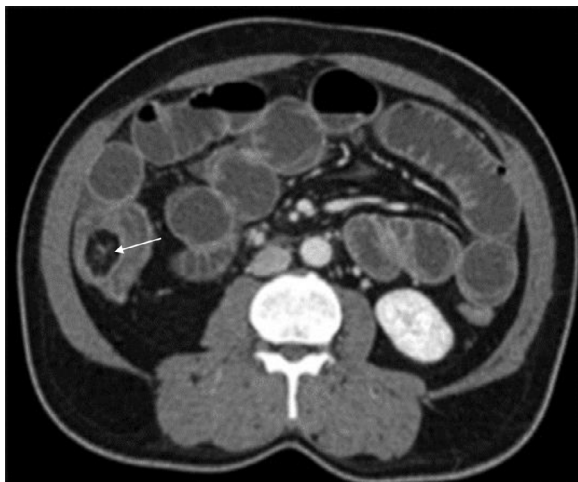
Axial CT scan showing a well-circumscribed intraluminal hypodense lesion with fat attenuation in the ileo-caecal junction (white arrow) with dilated proximal small bowel loops.
